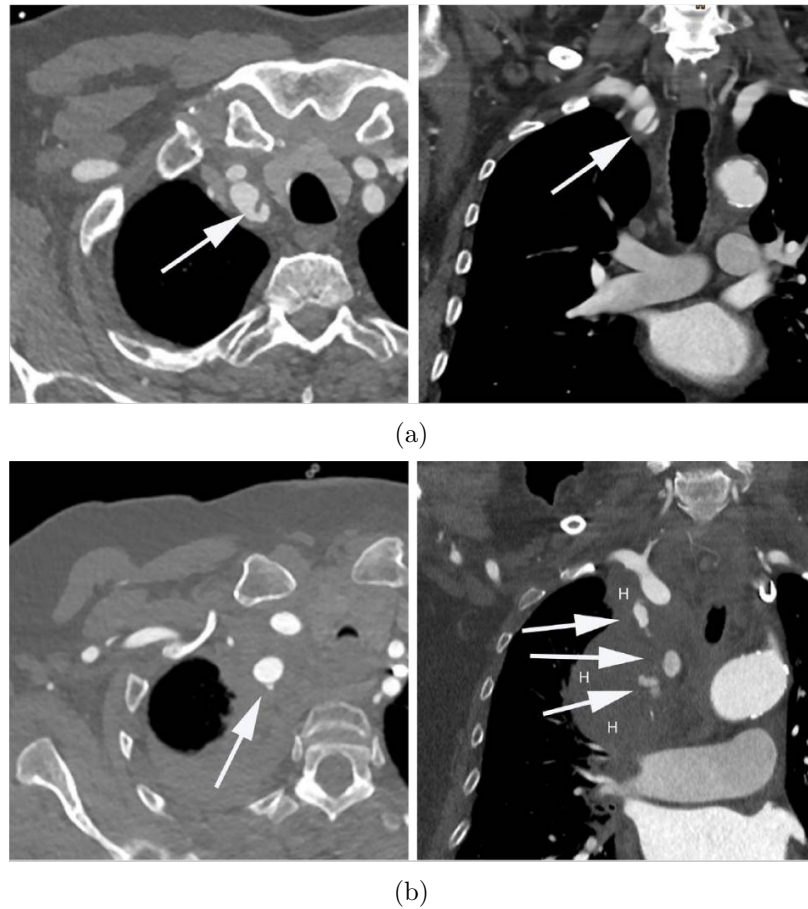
Examples of perforation and dissection in aortic arteries intervention (a) computed tomography showing dissection of the brachiocephalic trunk, (b) computed tomography showing perforation of the right subclavian artery [11].
